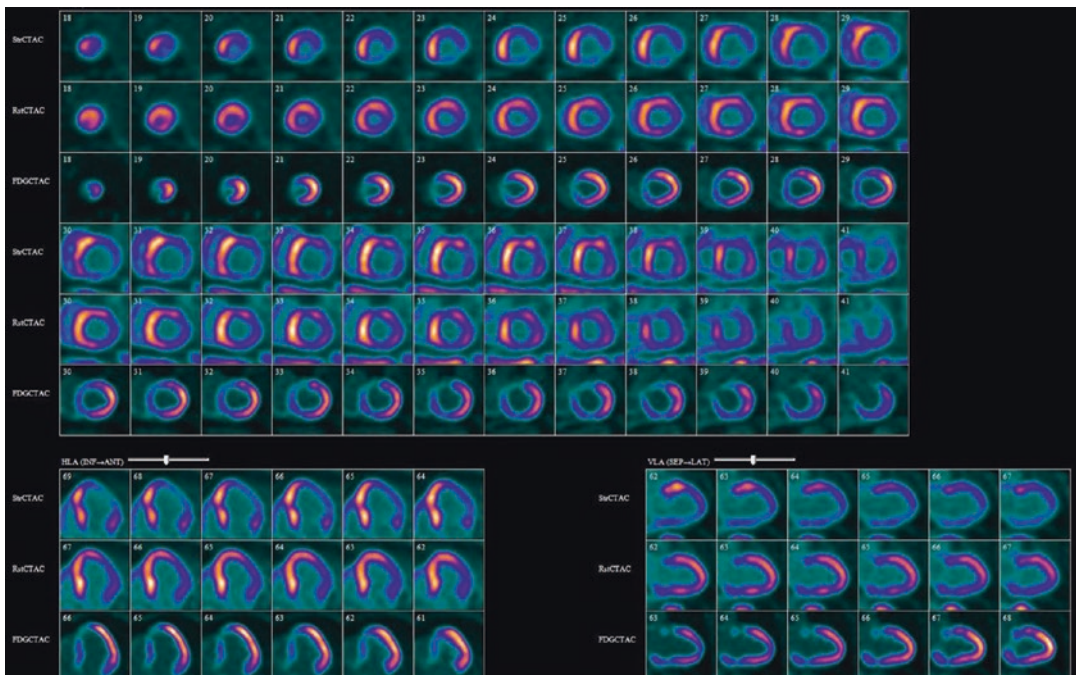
Rest and stress Rb-82 perfusion and F-18 FDG viability PET study showing extensive ischemia and viability in the anterior and lateral walls
